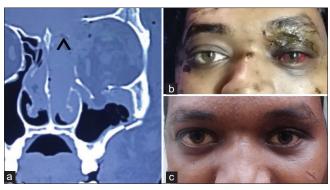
(a) Postoperative computed tomography coronal cut. (^) Shows the fascia lata spread across the defect. (b) One week postoperative picture of the patient which showed improvement of orbital signs. (c) Four months postoperative picture of the patient which showed complete resolution of orbital signs with very minimal enophthalmos
